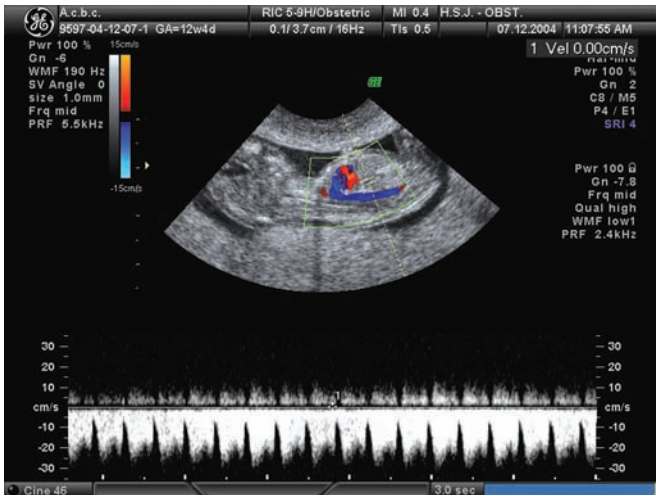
Doppler blood flow waveforms in the ductus venosus (DV) obtained in a monozygotic twin pregnancy at 11 weeks of gestation. Both DV waveforms were normal and NT were within normal range and non-discrepant. The pregnancy was uneventful and no TTTS developed.
